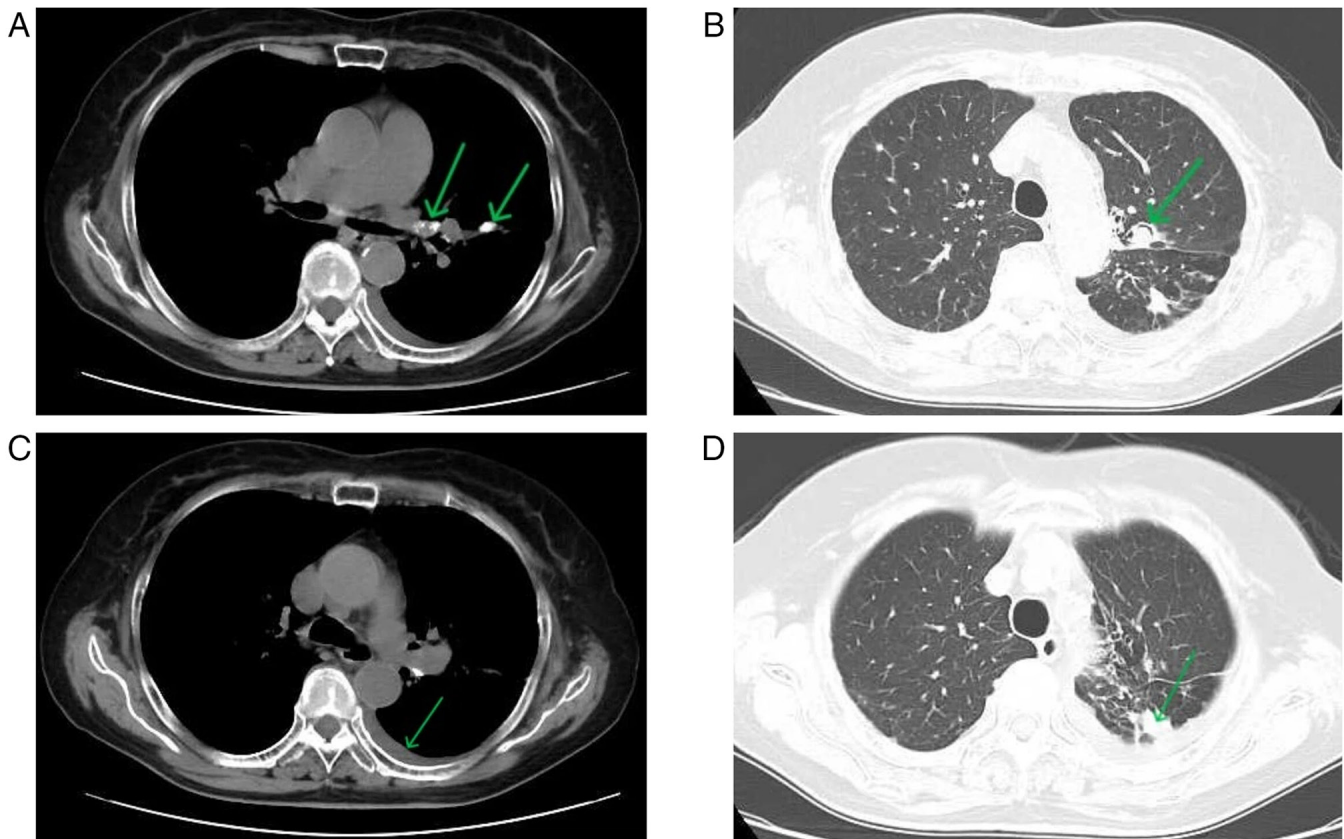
Imaging findings. (A) Calcified lymph nodes (indicated by arrows); (B) air crescent sign (crescent-shaped low-density area within a high-density nodule, indicated by arrow); (C) left pleural effusion (arcuate fluid density shadow, indicated by arrow); (D) left lung inflammatory lesion (patchy high-density shadow with ill-defined border, indicated by arrow). CT parameters: 120 kV, 80 mAs, 1-mm slice thickness, lung window (WL: -600 HU, WW: 1,500 HU), mediastinal window (WL: 40 HU, WW: 400 HU). CT, computed tomography; WL.
